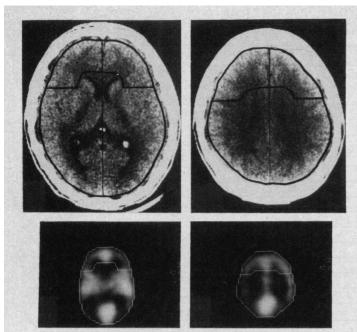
Regions of interest outlined on computed tomographs, based on anatomic criteria previously described, at levels of basal ganglia (top left) and semioval center (top right) were transferred to corresponding functional positron emission transaxial tomographic (PETT) images (bottom). Mean metabolic rate was then computed from PETT images for frontal and posterior reference regions.
